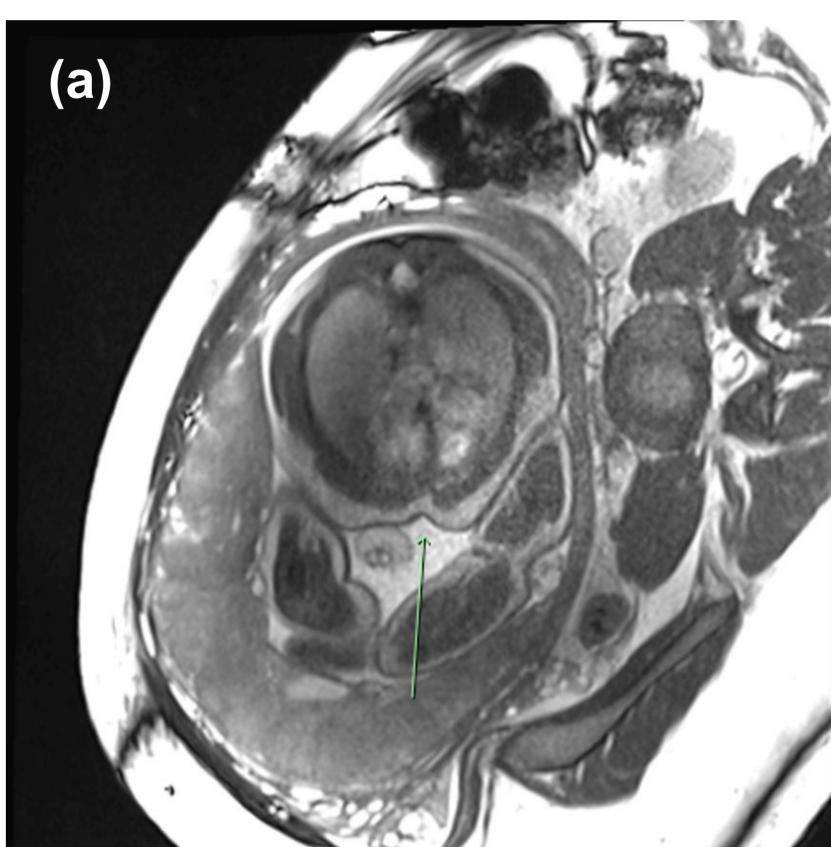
Multiphase fetal MRI images conducted at 37 weeks 5 days gestation. (a) Axial image, with arrowing showing central indentation of anterior inferior chest wall, corresponding to site of sternal defect on ultrasound (b) Sagittal image, with anterior bulge in the abdominal wall immediately inferior to the region described in (a).
